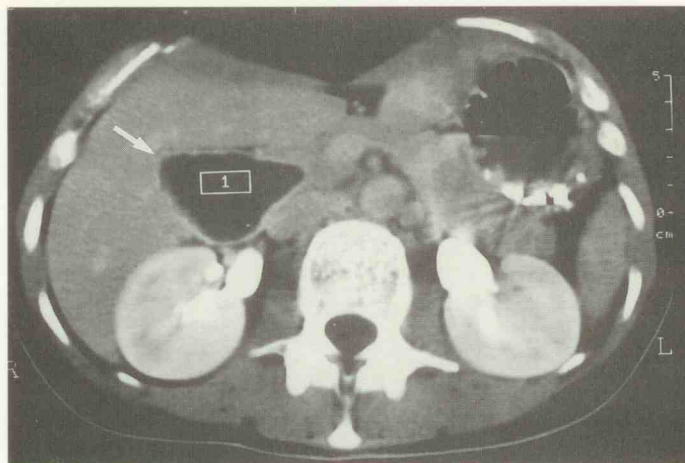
Abdominal computed tomography revealing a huge subhepatic cystic formation measuring 5 x 5 x 5 cm in size (arrow)
